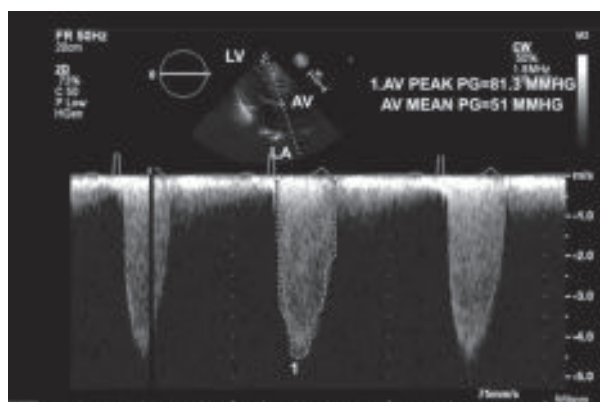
Two -dimensional transthoracic echocardiography. Aortic stenosis. Continuous wave Doppler through the AV shows peak and mean pressure gradients of 81 and 51 mmHg, respectively consistent with severe aortic stenosis.
